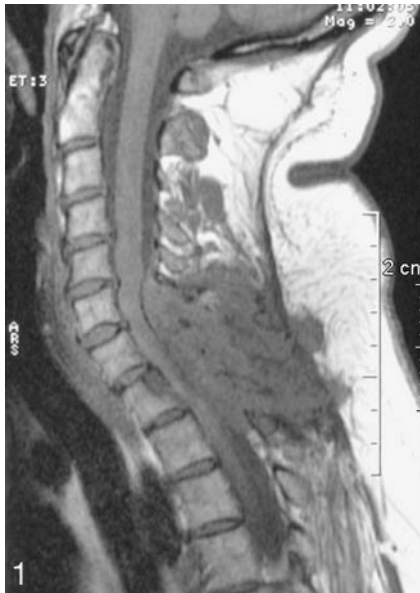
T1-weighted sagittal MR image shows a well-defined heterogeneous mass in the posterior cervical area between C6 and T2, with low signal intensity.
